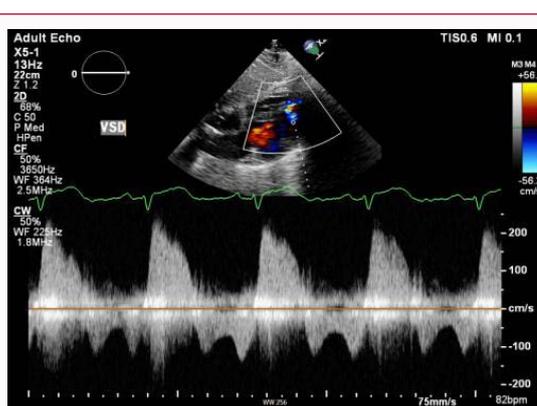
Subcostal view on TTE with continuous wave Doppler through apical VSD.
